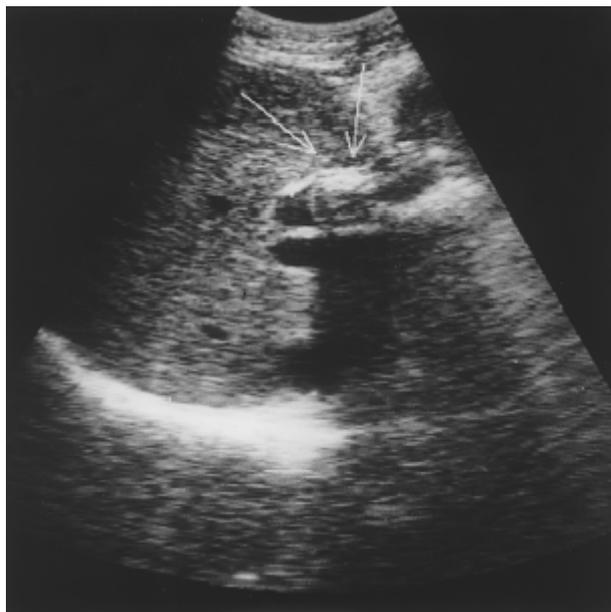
Abdominal ultrasonogram shows focal nodular echogenic lesion with acoustic shadowing and proximal ductal dilatation at common hepatic duct (Case 1).
